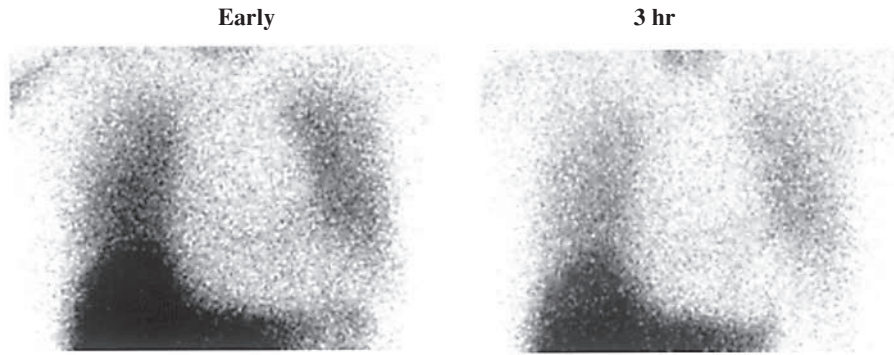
MIBG images from a 70-year-old patient with Parkinson's disease in Hoehn and Yahr stage I. MIBG scintigraphy, performed at 3 months after onset of symptoms, showed marked reduction of cardiac MIBG uptake in both early and delayed images.
